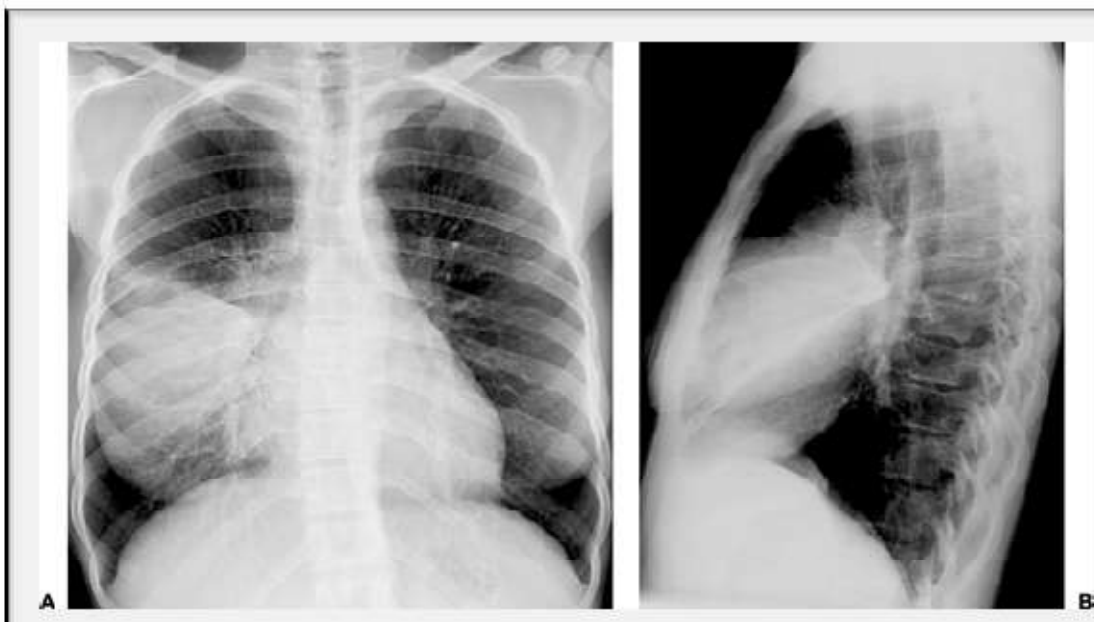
Lobar pneumonia due to *Streptococcus pneumoniae*. Posteroanterior (A) and lateral (B) chest radiographs show extensive right middle lobe consolidation.
